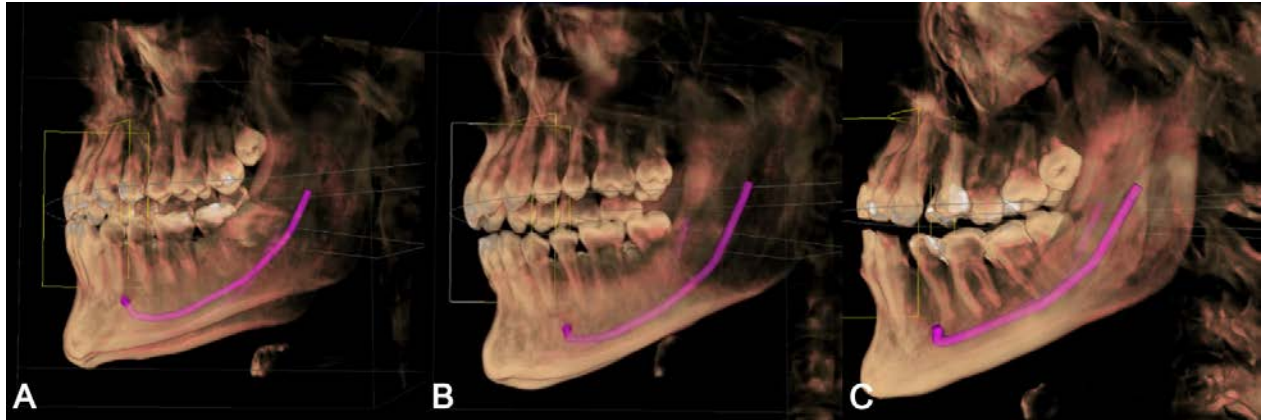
Different types of mandibular canals courses (A – catenary, B – descending, C – straight) (Original CBCT)
